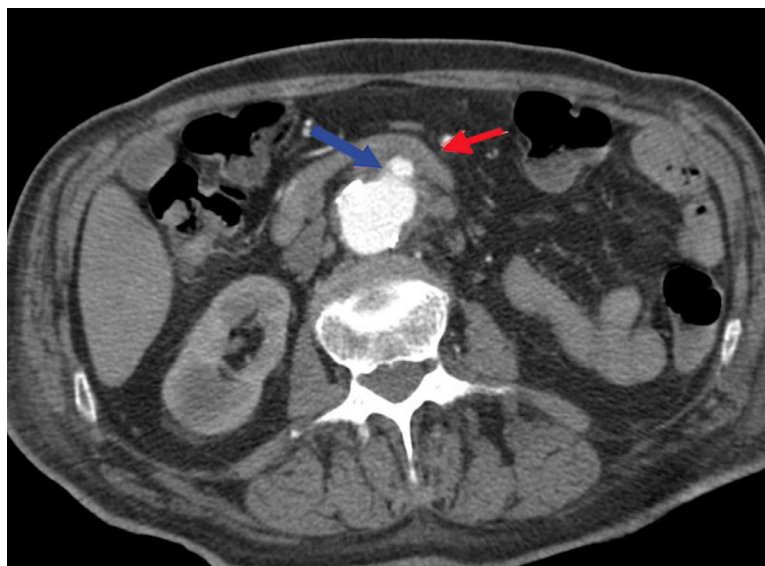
Axial computed tomography with contrast images (Arterial phase) showing the abdominal aortic aneurysm (Blue arrow) in close contact with the third portion of the duodenum (Red Arrow) with the presence of soft-tissue oedema surrounding the aorta and loss of the fat plane separating the aorta and the duodenal tract.
